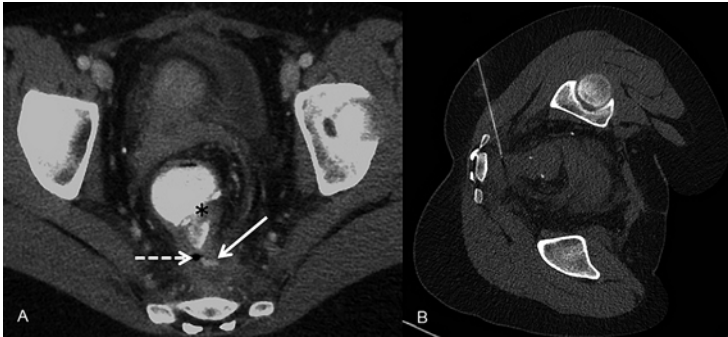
Axial CT image (a) with intravenous, oral, and rectal contrast at the level of the pouch-anal anastomosis (*black asterisk*) shows extravasated, extraluminal rectal contrast (*white arrow*) and extraluminal gas (*dashed white arrow*), diagnostic of leak. Unenhanced CT image (b) shows trochar needle approach for drain placement
